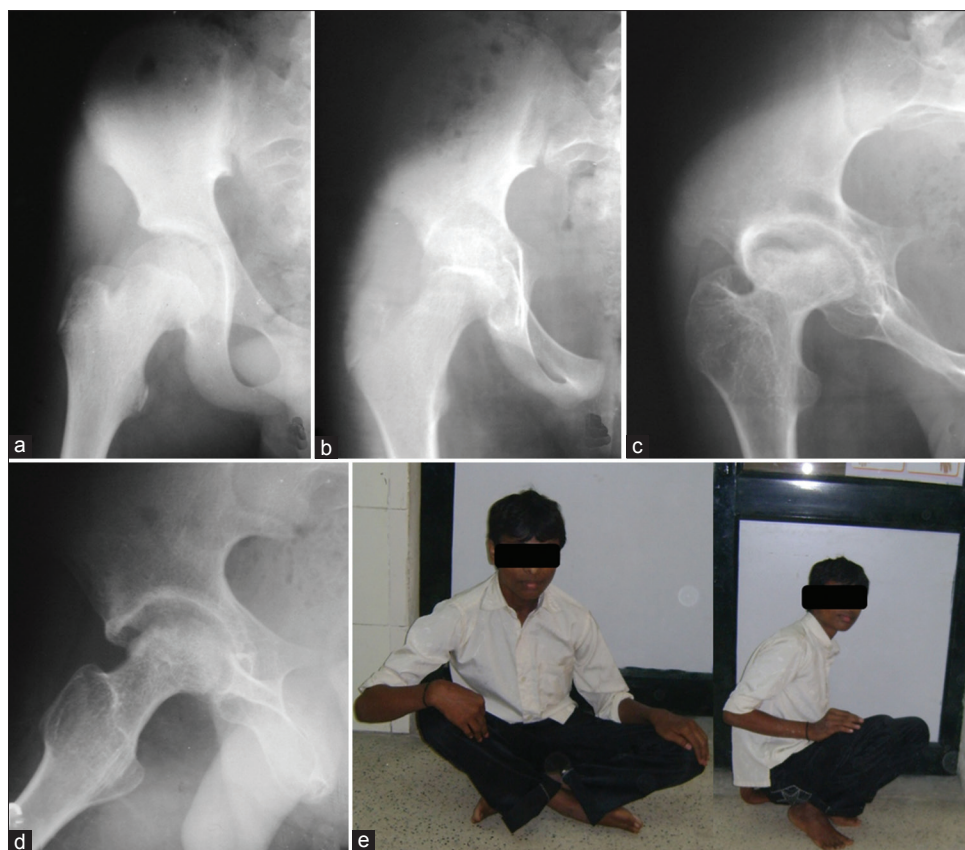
X-ray right hip joint anteroposterior view in a 11-year-old male child showing (a) pretreatment normal type. (b and c) Intermediate radiographs. (d) Posttreatment mortar pestle appearance. (e) Clinical photograph showing restricted crosslegged sitting and squatting
